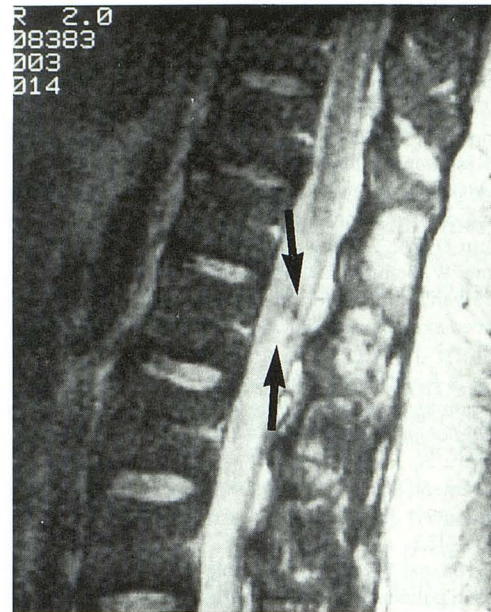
Sagittal fast spin-echo T2-weighted image (3000/96 effective/2.0; 256 × 256 matrix size; 3-mm section thickness; 1-mm interspacing) demonstrating abnormal heterogeneous signal within the lesion at the L-1 level (*black arrows*).
